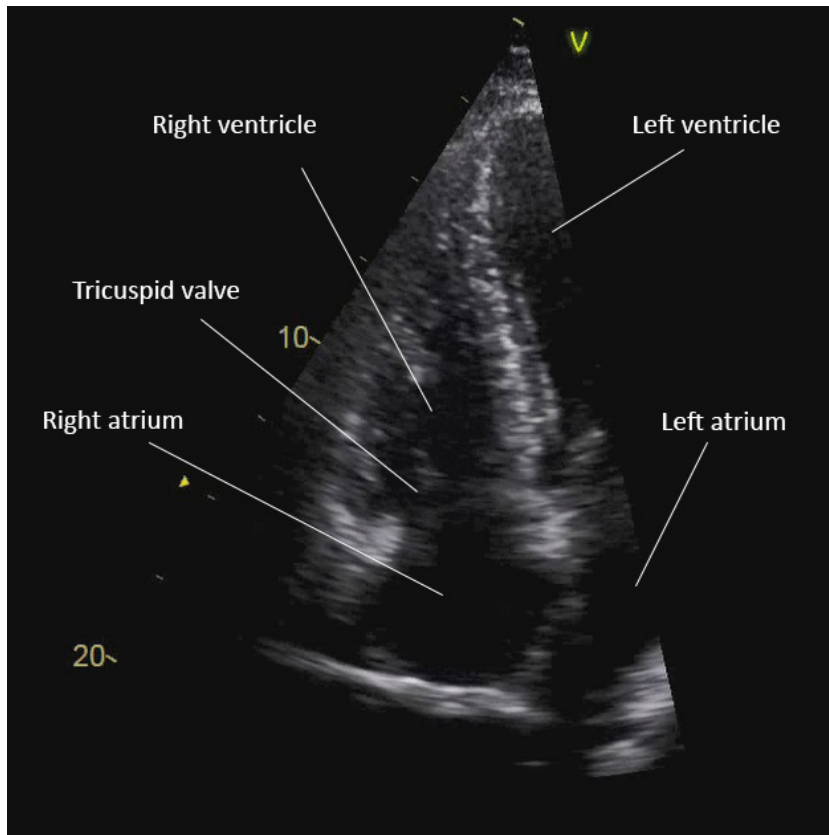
Visualization of the right heart and the tricuspid valve on a right ventricle-focused apical 4-chamber view on 2-dimensional transthoracic echocardiography
